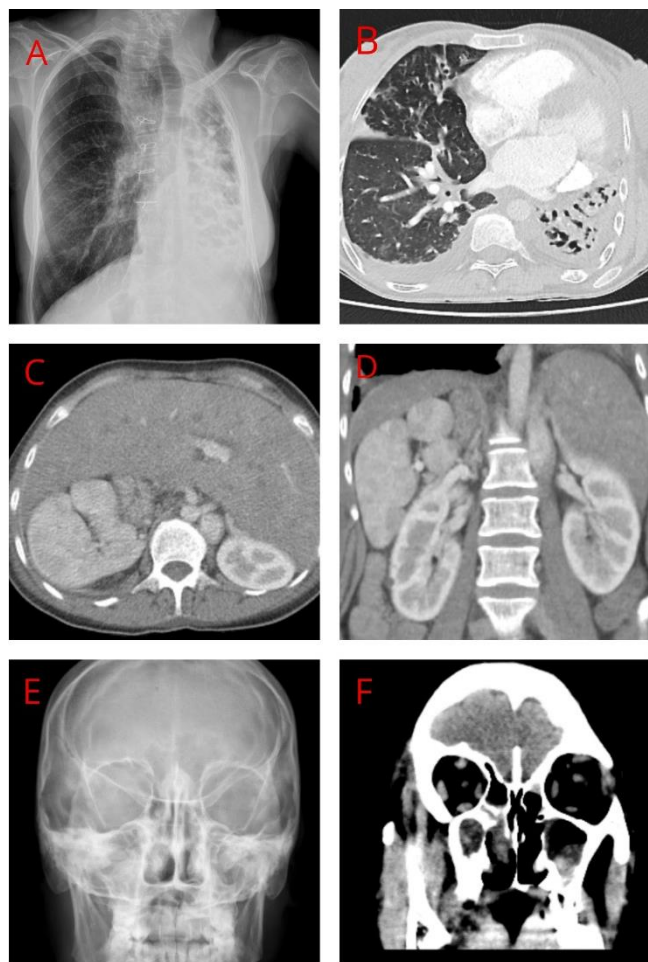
Chest X-ray (PAAG) showing left tracheal and mediastinal deviations, diffuse bronchiectasis in the left lung, increased air volume in the left lung and heterogeneous opacities in the right lower zone (A); A chest computed tomography (CT) scan revealing a displacement of the heart and mediastinum to the left, diffuse atelectasis in the left lung, cystic and tubular bronchiectatic changes in both lung fields, and bilateral pleural effusion (B); Abdominal CT revealing the midline position of the liver and the right lower quadrant location of the spleen. Appearances compatible with multiple splenosis were also observed, the largest of which was 75x40 mm in size (C, D); Water's radiography taken during an examination for a chronic upper respiratory tract infection showed air-fluid levels and poor visualization of air spaces in the right maxillary sinus, while paranasal sinus CT revealed mucus retention cysts and mucosal thickenings in the paranasal sinuses (E, F)
